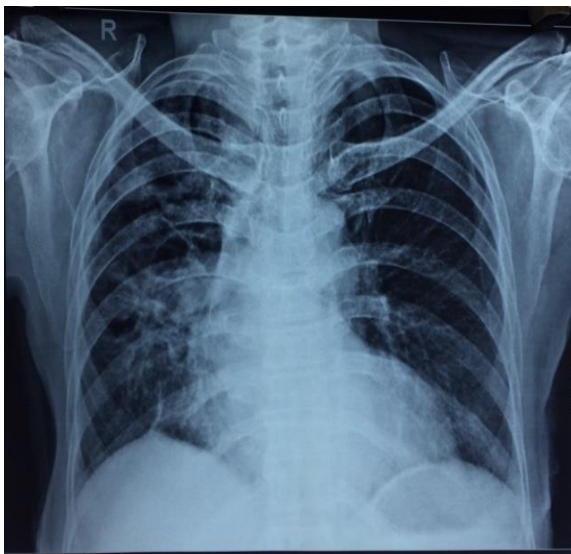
chest X-ray showing fibrotic changes on right side with a patch of consolidation
